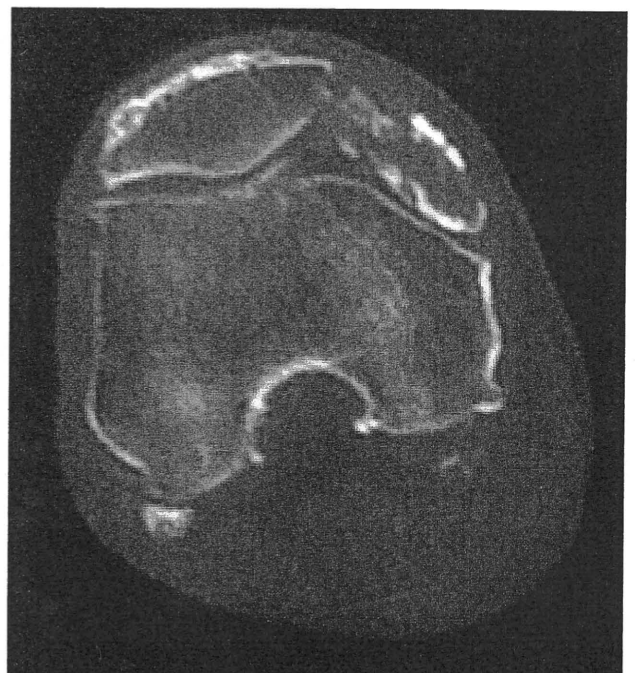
Computed tomography showing irregular and marginal calcification around the mass in the medial para-patellar joint space.
